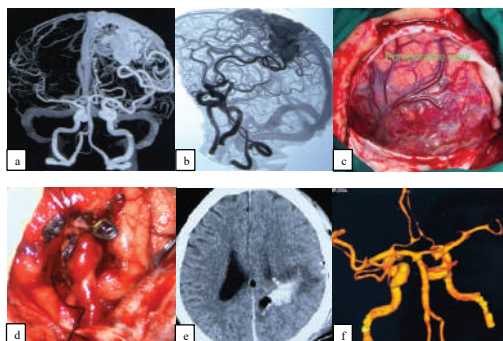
A 72 year-old male with left parietal AVM. TRCTA (a) antero-posterior and (b) left oblique view show multiple feeding vessel arise from both ACA and MCA, feeding a huge compact nidus of about 7x 6.5 x 4 cm in diameter with presence of intranidal aneurysm. The AVM is draining into SSS (Spetzler-Martin grade 4). (c) Intra-operative photograph showing gross appearance of the malformation after retraction of dural flap. (d) Complete resection with hemostasis ensured in the resection bed. (e) Patient developed a small resection bed hematoma at post-operative CT scan which later on spontaneously resolved. (f) 3DCTA ensured complete resection of the malformation. Here, AVM: arteriovenous malformation; TRCTA: time resolved computed tomography angiogram; ACA: anterior cerebral artery; MCA: middle cerebral artery; SSS: superior sagittal sinus; 3DCTA: 3 dimensional computed tomography angiogram.
